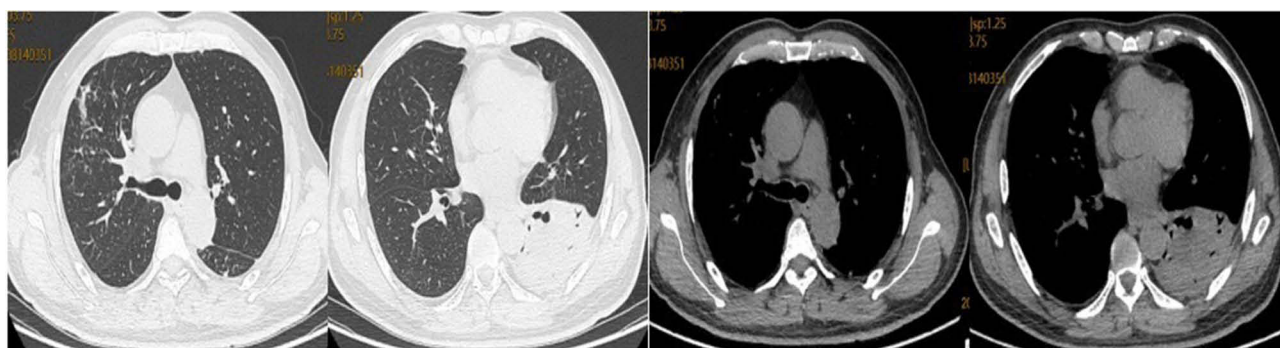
The chest CT images showing double pneumonia with left lung lesions, lower left lung bronchiectasis, bilateral chronic lung inflammation, and fibrous foci.
